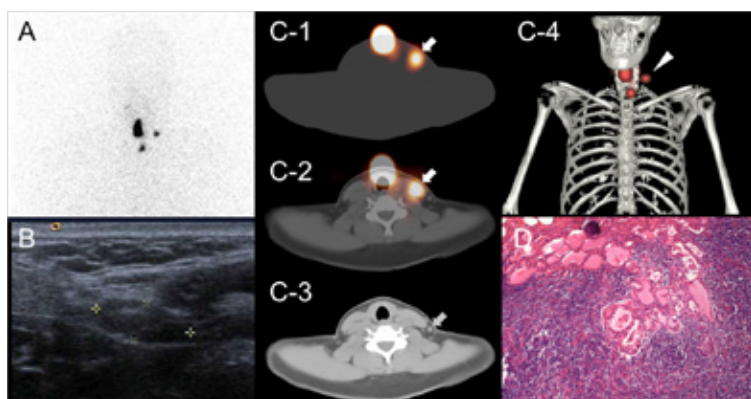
Second surveillance for recurrence performed at 14 months after total thyroidectomy. A, B: Findings of diagnostic ^{123}I scintigraphy and US of the neck were almost the same as on the first surveillance. C-1: ^{123}I SPET and C-2: SPET/CT visualized a focal radioiodine uptake (white arrow) in left lateral neck. C-3: neck CT of SPET/CT visualized a lymph node (gray arrow) at a little lateral to the radioiodine uptake on C-2 image. C-4: maximal intensity projection fusion on 3D scan of bone CT image of the SPET/CT also well visualized the high uptake focus (arrowhead) at left lateral neck. D: After left lateral neck dissection this "hot" lymph node was pathologically confirmed as PTC metastasis.
